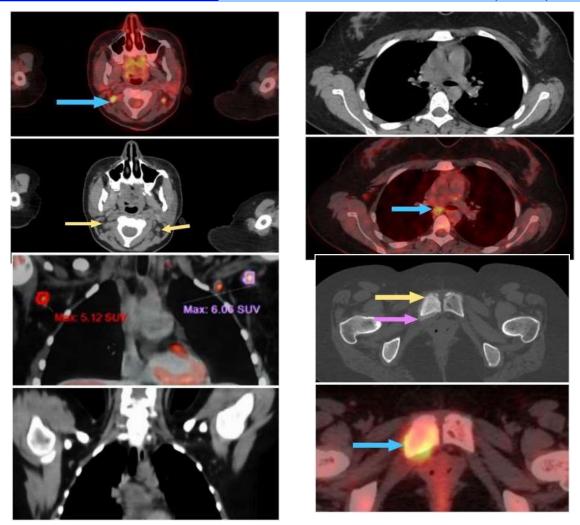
A 15 years old female patient with biopsy-proven left femur Ewing sarcoma, underwent surgical excision followed by chemo-radiotherapy for 3 months and refereed for follow up. (A): Axial CT & fused PET /CT neck show newly developed multiple metabolically active bilateral cervical lymph nodes (yellow arrow) with the most avid nodal lesion at the right side achieving SUV max of 5.4 (blue arrow). (B): Axial CT study of chest shows no pathologically enlarged mediastinal lymph nodes however fused PET/CT shows prevascular, pre-tracheal and subarinal (blue arrow) metabolically active lymph nodes achieving SUV max uptake of 2.3 denoting role of PET/CT in detection of micronodal metastasis. (C): Coronal CT & fused PET/CT chest show multiple bilateral enlarged axillary lymph nodes with high FDG uptake achieving SUV max up to 6. (D): Axial CT & fused PET/CT pelvic bones show right pubic bone ill-defined sclerotic lesion (yellow arrow) with periosteal reaction (purple arrow) achieving high FDG uptake with SUV max of 8.6.
